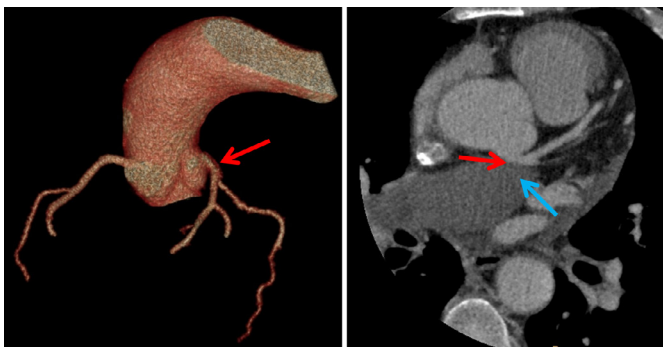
In coronary computed tomographic angiography images, the red arrow in the left figure shows the left main coronary artery. In the right figure, the red arrow indicates external compression by the pulmonary artery to the left main coronary, and the blue arrow indicates the compressing pulmonary artery.
